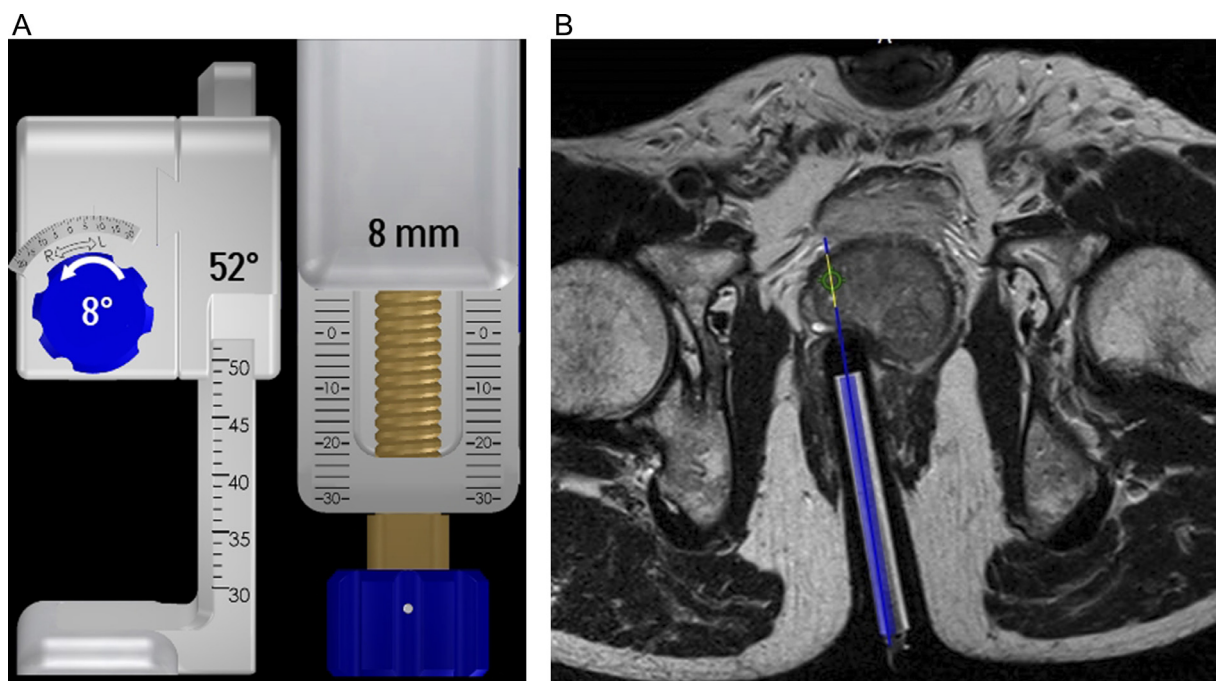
(A) Dynacad software demonstrated the desired coordinates for biopsy including Right/Left, Anterior/Posterior, and Head/foot. (B) Corresponding imaging on the confirmatory MRI demonstrating the needle guide to be aligned with the desired lesion prior to biopsy. (Color version of figure is available online.)
